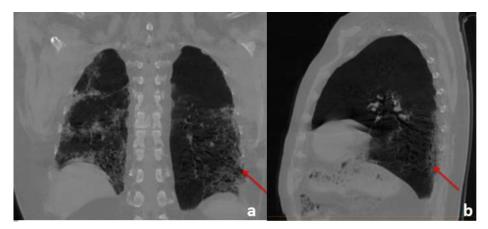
Coronal (a) and sagital (b) thin-section unenhanced baseline CT with minimum intensity projection (MinIP) showing bronchiolectasia in the pathological areas (red arrows)
